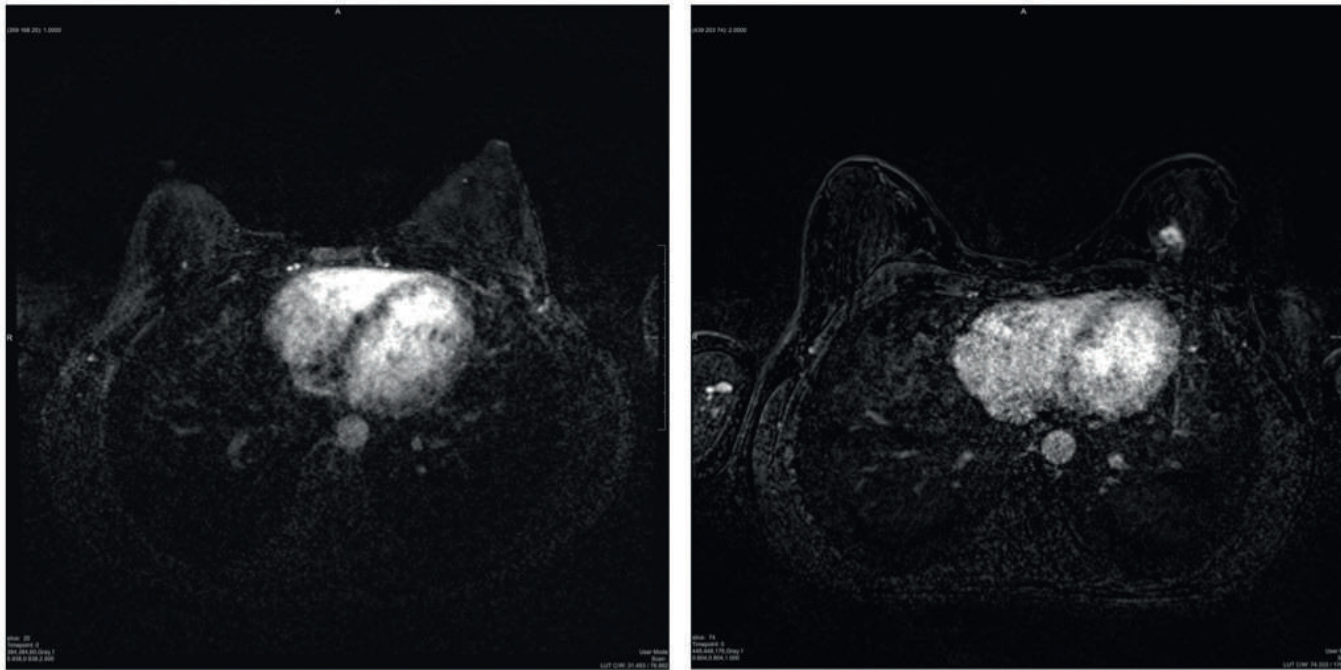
Two MRI acquisitions of suspicious areas which lead to a biopsy. Both images are of young women with a BRCA1 mutation. Left a TWIST acquisition with a BI-RADS 3 lesion centrodorsal in the right breast which was proven to be a small fibroadenoma. To the right a VIBE acquisition of a BI-RADS 4 lesion. The pathology was proven to be an inflamed cyst. Both lesions were declared not suspicious by the CAD system.
